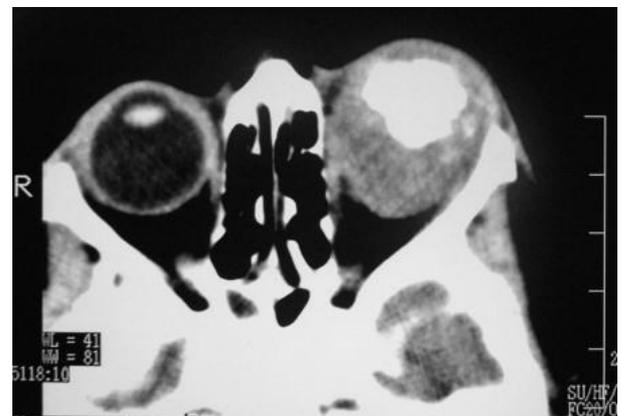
CT Scan of orbit showing a well-defined mildly enhancing mass lesion.
